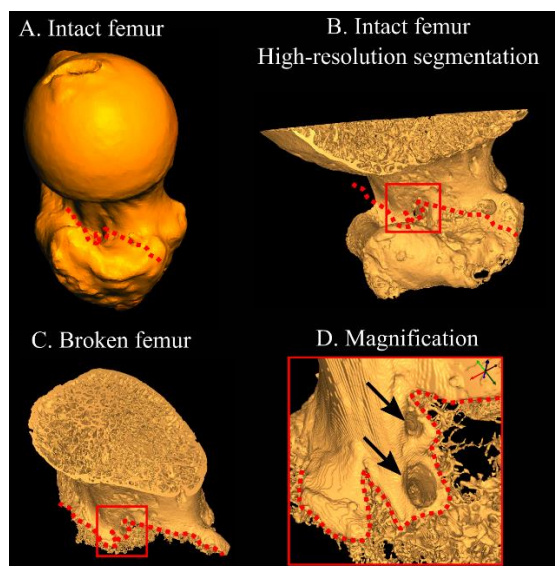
Segmentations of: A) an intact proximal femur; B) the μ CT scan of the same intact femur; C) the μ CT scan of the broken femur. D) A magnification of the fracture near foramina. The red dotted lines indicate the fracture line. The black arrows point at foramina.
